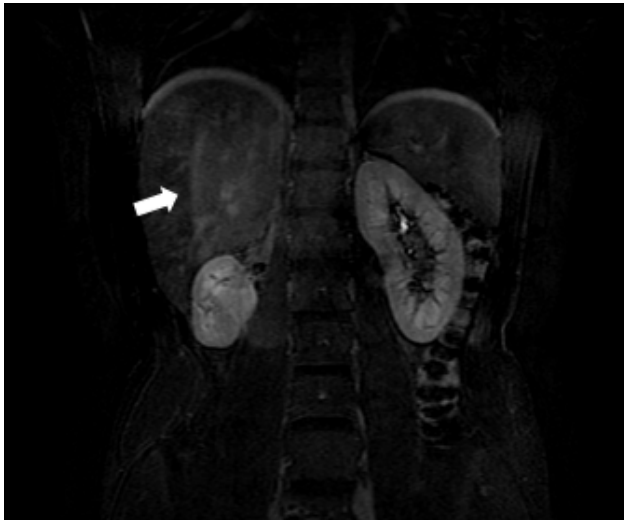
T1-weighted contrast enhanced coronal MR image. Small remnant right kidney with normal contrast perfusion on venous phase.
